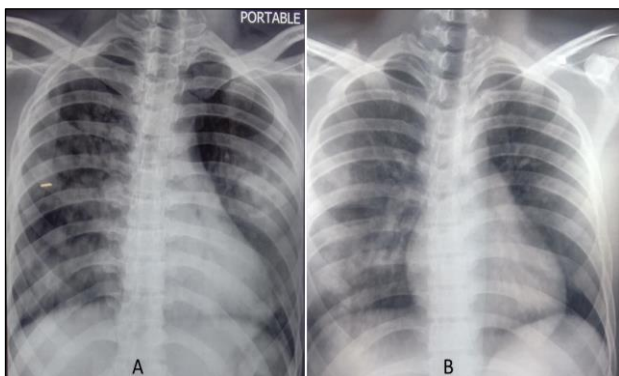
X-ray chest of the patient on admission (A) and after 4 days (B).
